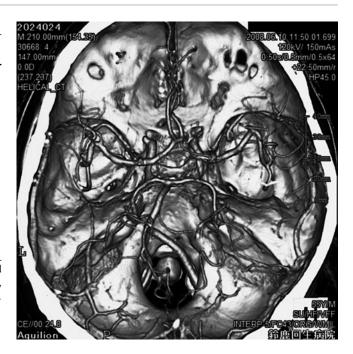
Preoperative contrast-enhanced CT scans showing left ICA aneurysm arising from the anterior wall
